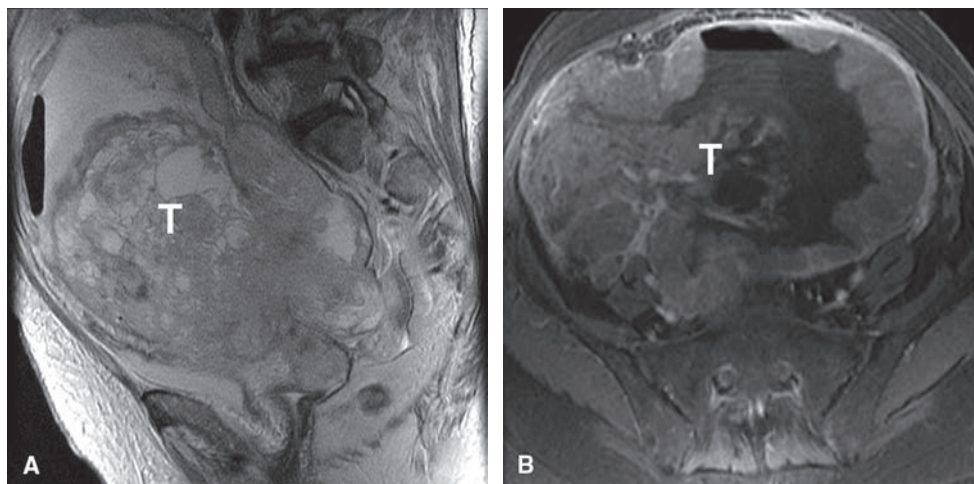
Leiomyosarcoma. Sagittal T2W FSE (A) and axial gadolinium-enhanced 3D T1W GRE (B) MRI images show an enlarged heterogeneous uterus (T in A, B) with areas of necrosis in keeping with a leiomyosarcoma.
